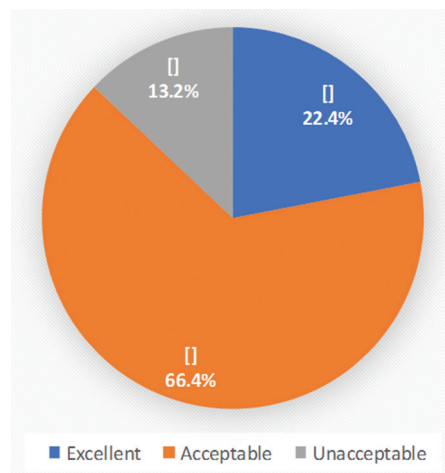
Subjective quality rating of radiographs in the studied sample
